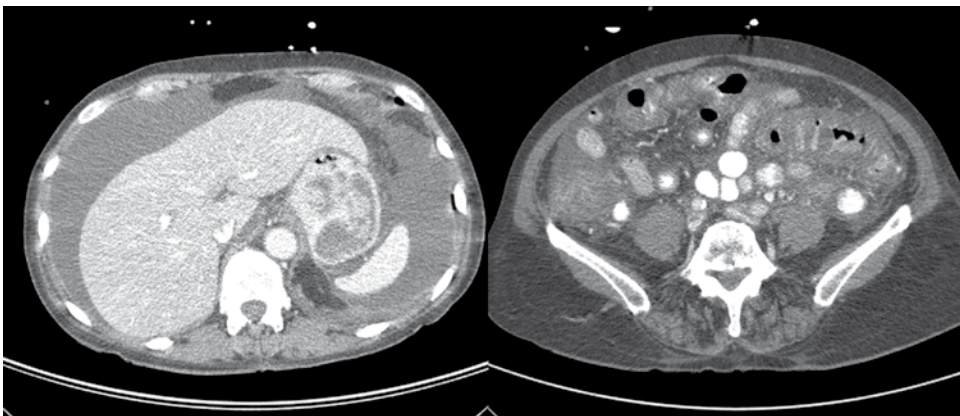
CT abdomen scan showing a large volume of free fluid and bowel wall oedema.
